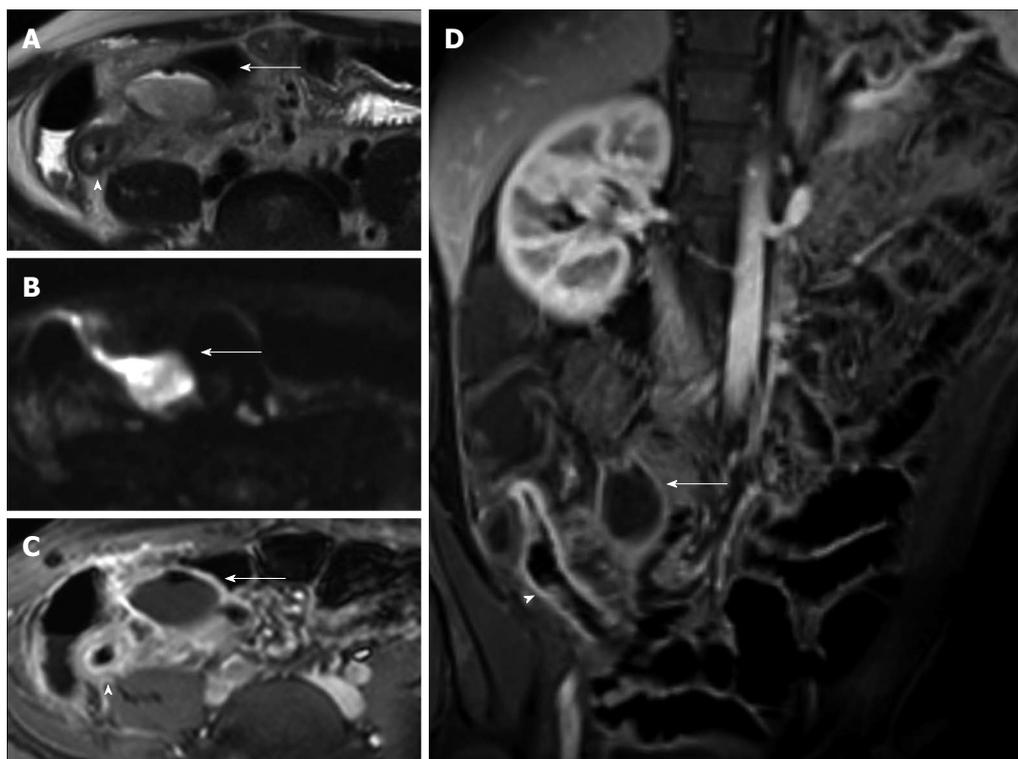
Eighteen-years-old female with active Crohn's disease and abscess. Transverse T2-w (A), DWI (B), transverse (C) and coronal (D) post-contrast FS-T1-w image (C) show inflamed segments of the terminal ileum (arrowhead) with pericecal fluid-collection around thickened and hyper-vascular walls (arrow), according to abscess. A small air bubble in the antideclive portion of the fluid collection is visible in the transverse T2-w (A) and transverse post-contrast FS-T1-w image (C).
